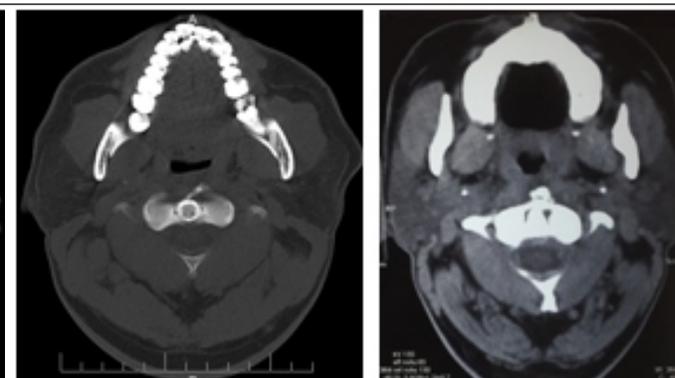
Computed tomography axial images – (a) and (b) arrows showing calcific deposition at the insertion of superior oblique longus colli muscle.
